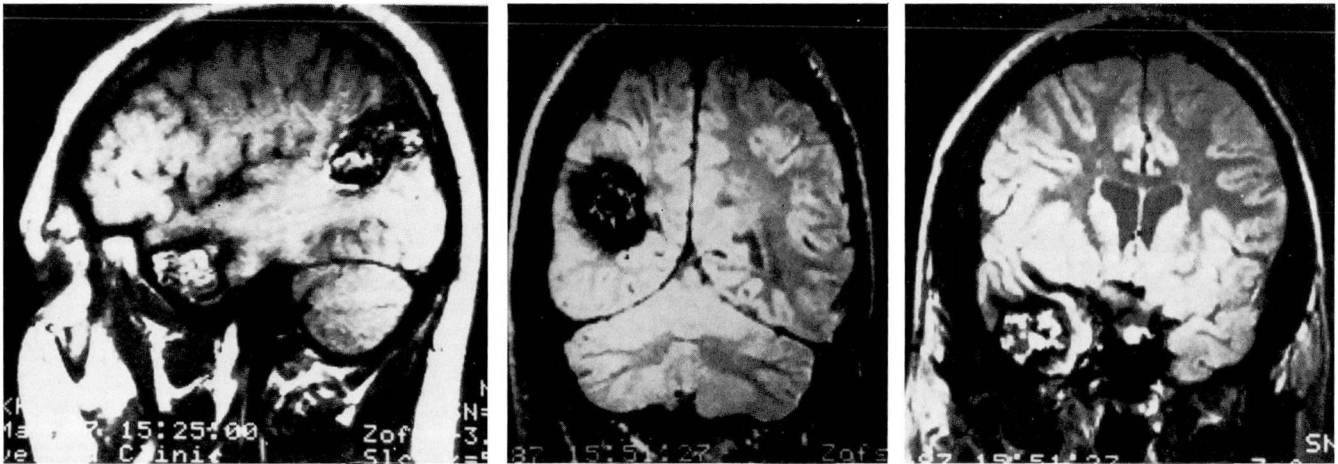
Right-sided cavernous hemangiomas (MRI).
